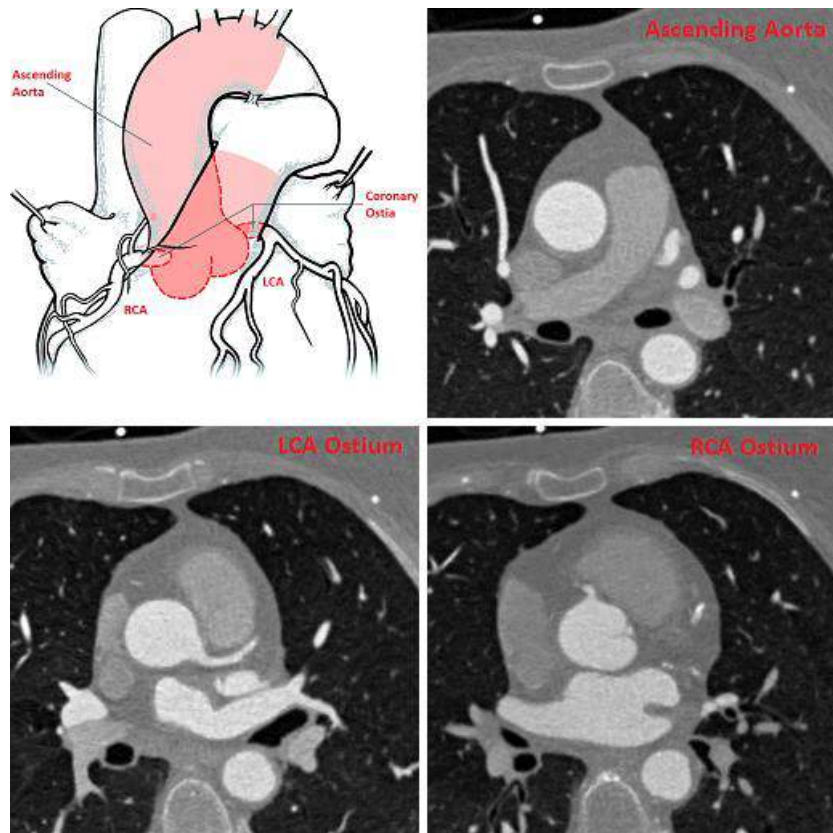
Sample CT slices from a training volume with the ascending aorta and LCA and RCA ostia shown.
